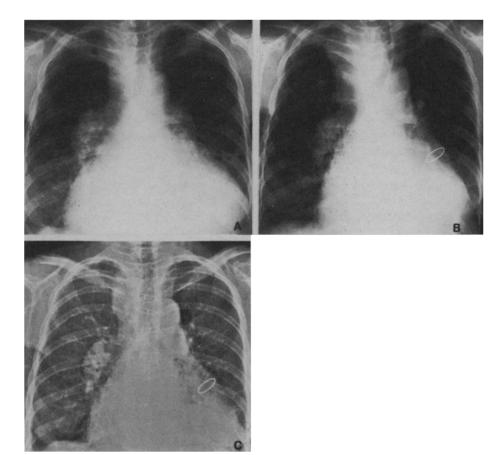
Case 2. Chest roentgenograms before (A) and after (B) correction of tetralogy of Fallot, but before repair of aneurysm. C, 5 months after repair of aneurysm. Note the partial resolution of superior mediastinal widening.
